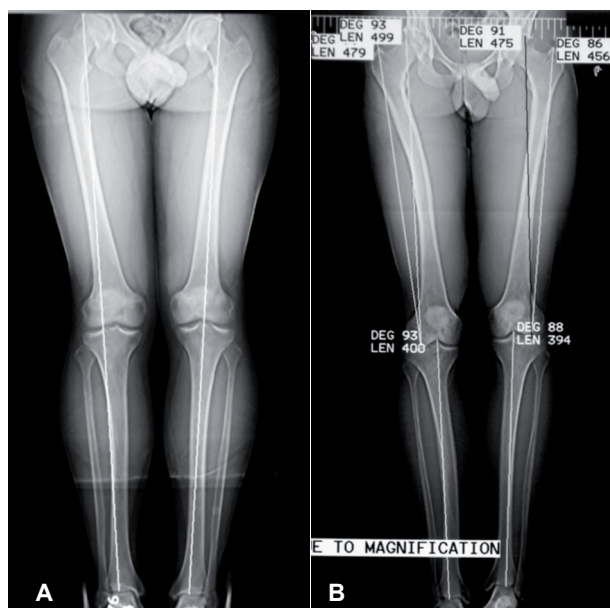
X-rays done for an accurate LLD measure, assessing possible axial deformity and physal closure 2A. Patient with full correction 2B. Patient with 23mm femur and 6mm tibia shortening.
